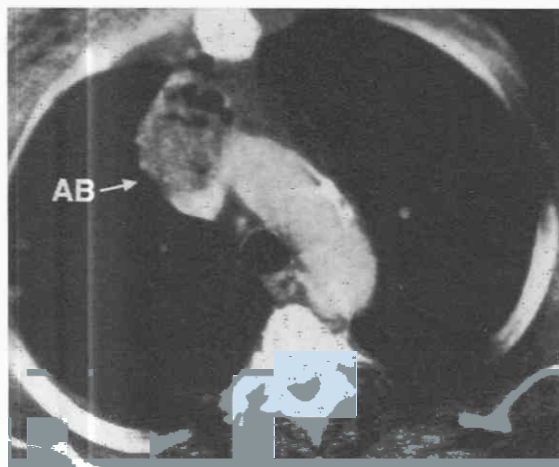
Descending cervical mediastinitis. CT shows air-containing mediastinal abscess (AB) that extended from an abscess in the neck.
